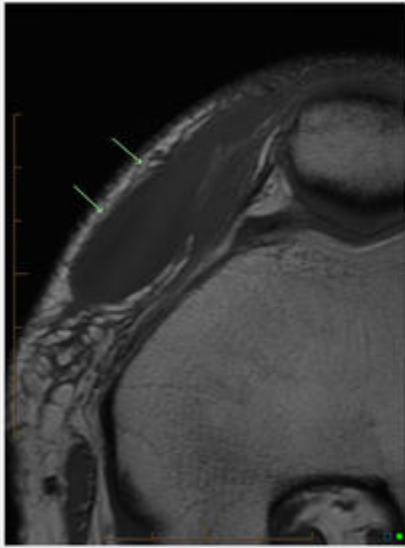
Axial magnetic resonance imaging slice reveals a medial bursal effusion and subcutaneous edema.
